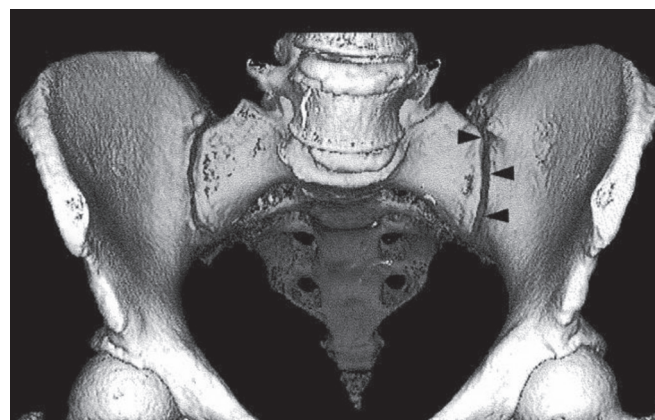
CT scan of sacroiliac joint—posterior view
